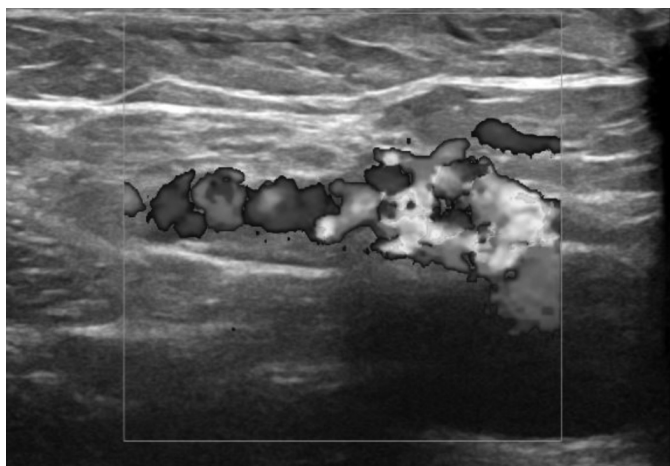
Color Doppler evaluation residual incompetent cross-stump.
